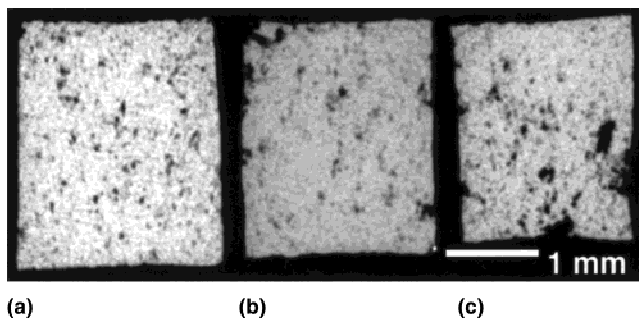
(a–c) Three images from UHR x-ray CT data slices are presented. The images correspond to slices at positions a, b, and c, respectively, of Fig. 1.
